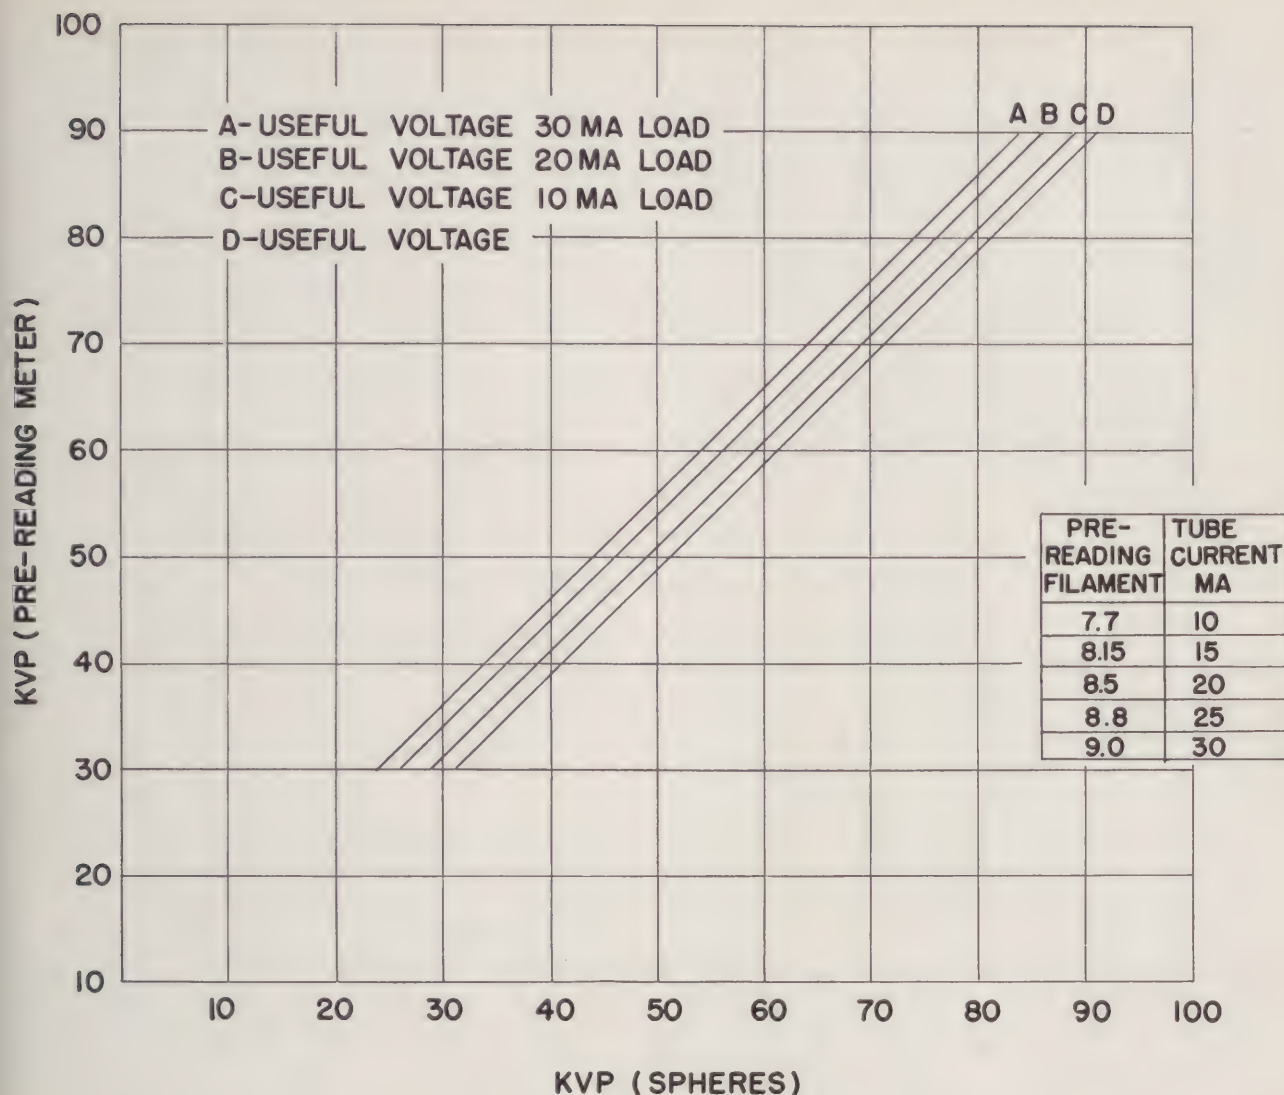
Average kilovoltage calibration for field X-ray units, Item 96085 (10 machines).
